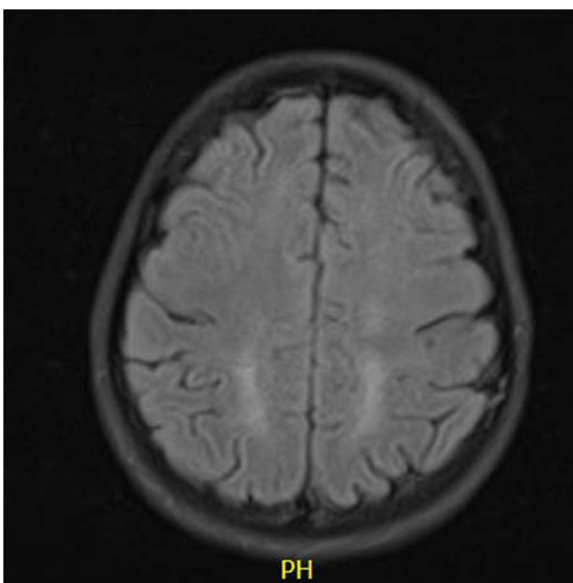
Axial T2 Flair on magnetic resonance imaging (MRI) of the brain.
